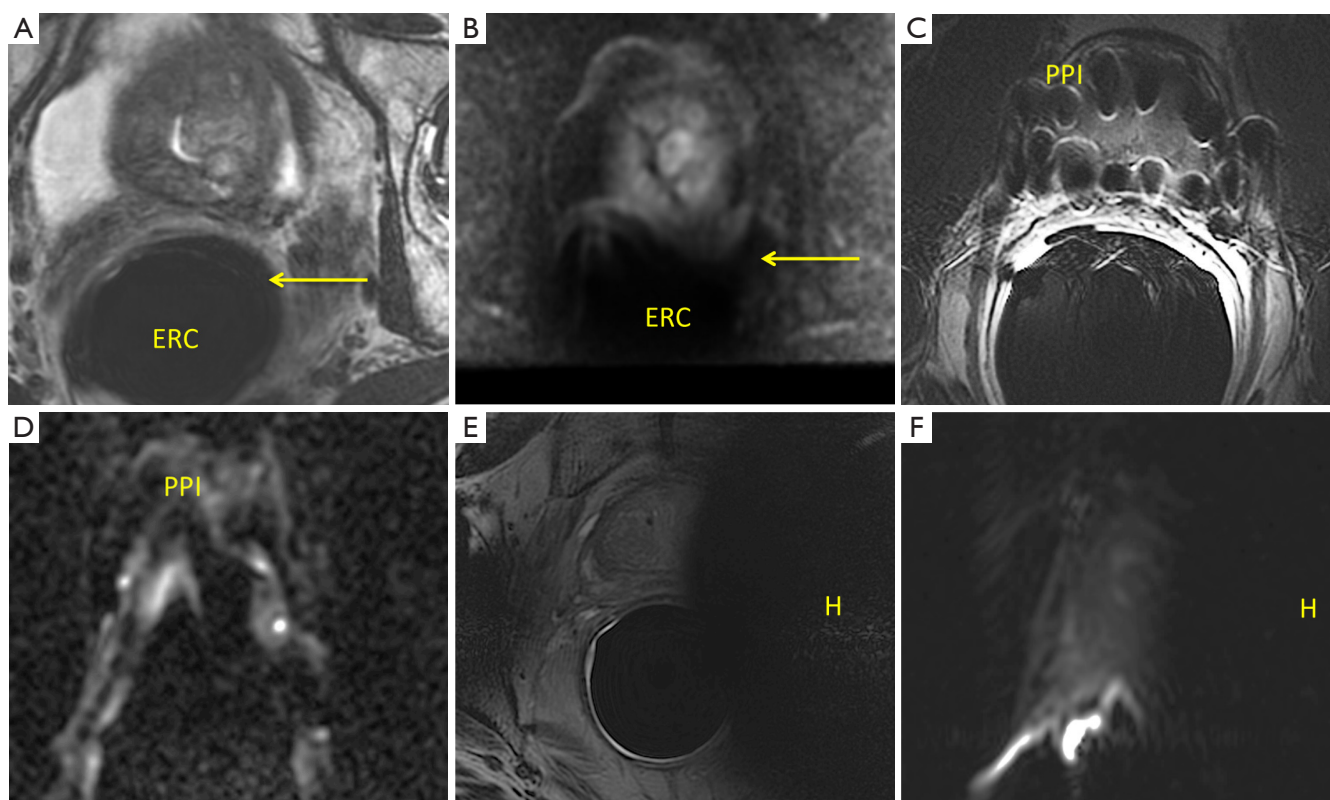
Examples of the effects of susceptibility artifact on axial T2WI and DWI. In *Figure 5A*, an endorectal coil (ERC) is in place. However, adjacent to the coil, there is a small volume of colonic gas—a crescentic area of low signal external to the coil (arrow)—that results in distortion of the prostate on DWI (B). Metallic objects may also cause susceptibility. The presence of multiple permanent prostatic implants of brachytherapy (PPI) and hip prostheses (H) can cause susceptibility artifact that limits evaluation on T2WI (C,E), however the DWI sequence is more sensitive to this artifact and rendered non-diagnostic (D,F). T2WI, T2-weighted image; DWI, diffusion-weighted MR imaging.
